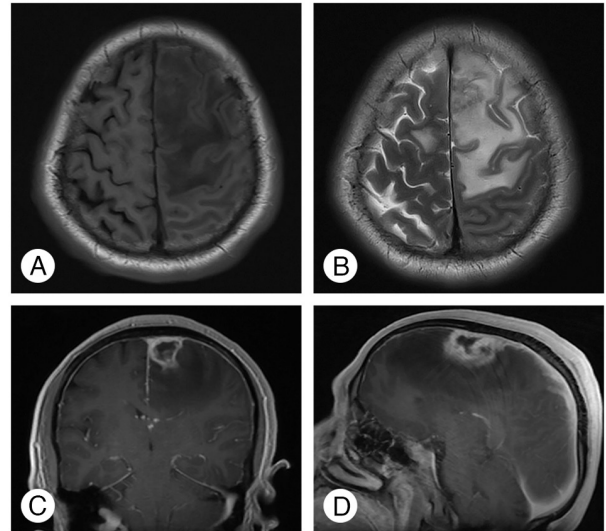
Preoperative brain magnetic resonance imaging scans. (A) Axial T1-weighted image demonstrating a hypointense mass in the left frontal lobe. (B) Axial T2-weighted image showing the left frontal lobe lesion with extensive surrounding hyperintense edema. (C) Contrast-enhanced coronal T1-weighted image revealing prominent ring enhancement of the lesion. (D) Contrast-enhanced sagittal T1-weighted image demonstrating the close relationship between the lesion and the adjacent dura mater.
